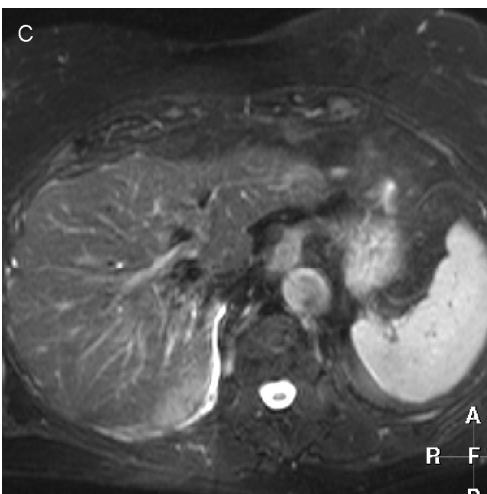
T2-weighted MR image shows complete remission with morphological parenchymal changes due to radiation hepatitis 21 months after treatment.
